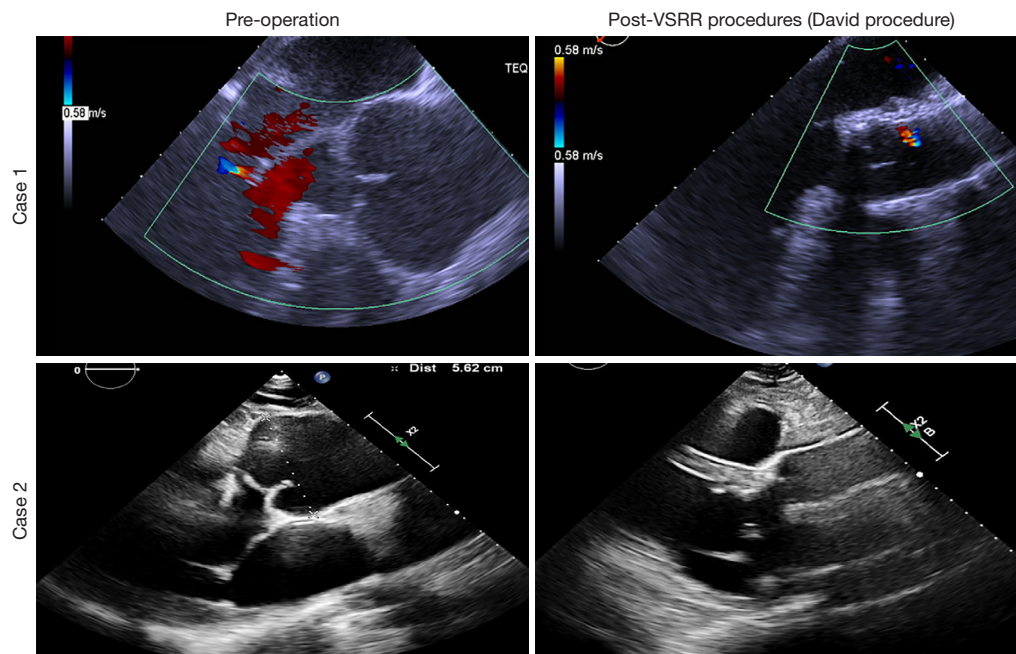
Echocardiographic images before and after surgery. VSRR, valve-sparing root replacement; TEQ, tissue equalization; Dist, distance.
